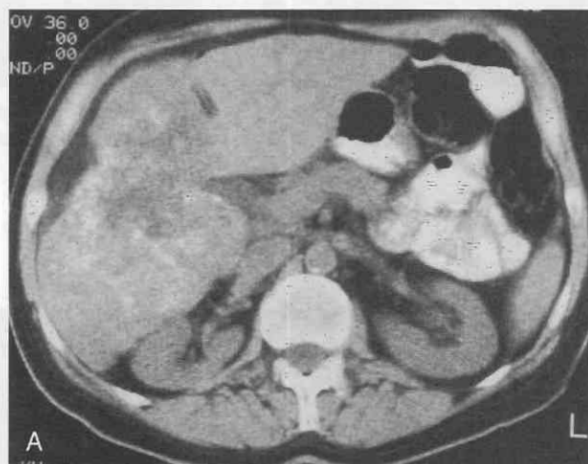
Metastatic carcinoma of the sigmoid colon in a 57-year-old man. *A*, Noncontrast CT scan demonstrates a large area of increased and decreased density of the liver that represents calcifications in a large metastatic lesion. A small amount of perihepatic fluid is present. *B*, Contrast-enhanced CT scan makes detection of the calcifications somewhat more difficult because of enhancement. The low-attenuation lesion, however, is now better defined. *C*, The sigmoid colon carcinoma (*arrow*) responsible for the metastatic lesion is shown.
